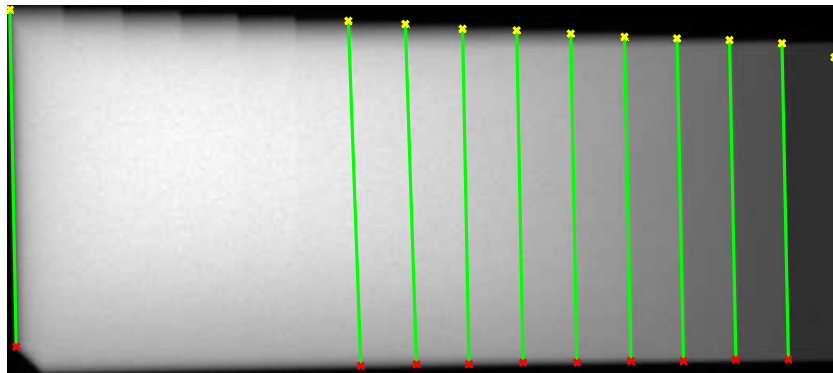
The X-ray image of the wedge showing the selected step boundaries (green). Start (yellow) and end (red) co-ordinates are also marked.
